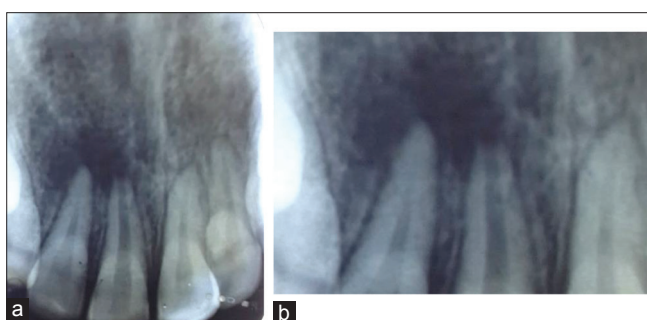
(a and b) Pre-operative radiograph
